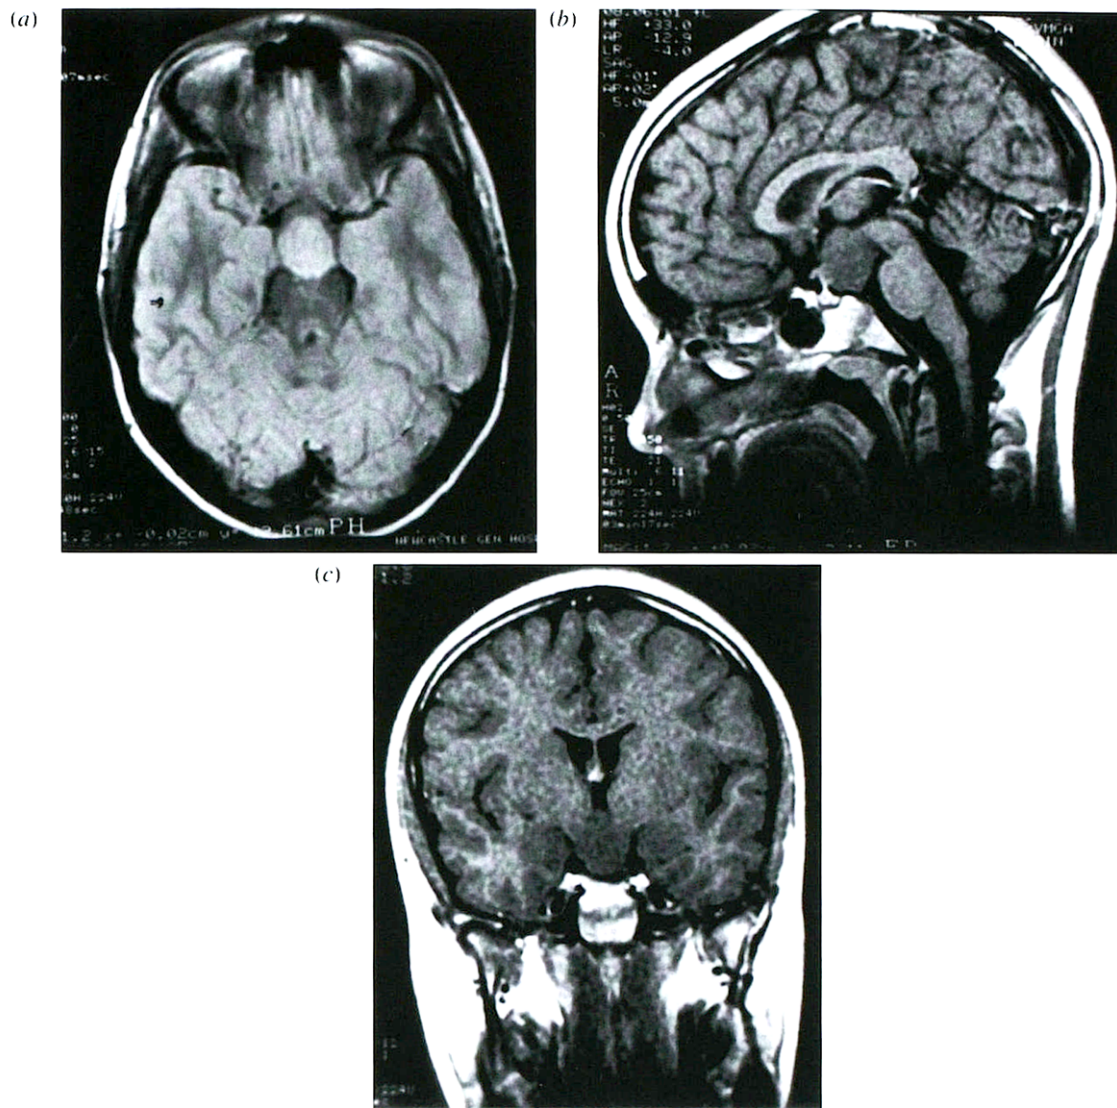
a–c. Axial, sagittal and coronal MRI studies of Case 1 showing large midline hypothalamic mass.
